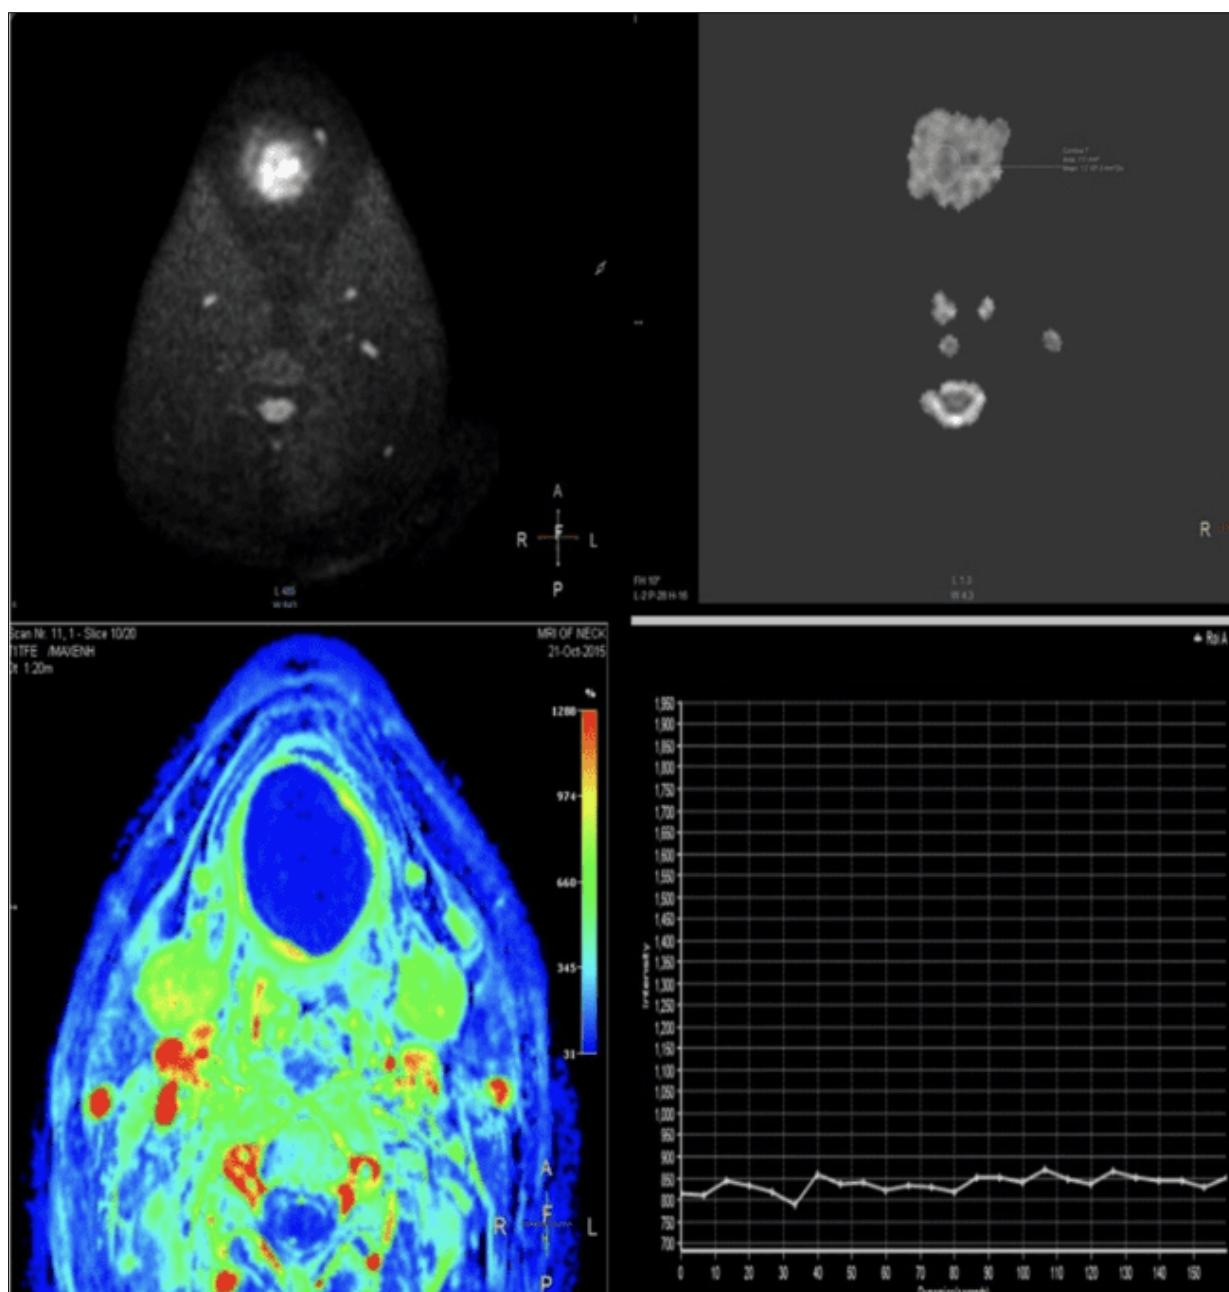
Case of Pleomorphic adenoma. The upper row shows diffusion restriction on diffusion-weighted images ( $b=800 \text{ mm}^2/\text{s}$ ), with the corresponding area showing low values for the ADC image. The ADC value of the lesion was measured as  $1.4 \times 10^{-3} \text{ mm}^2/\text{s}$ . The lower row DCE-MRI shows Type B TIC
